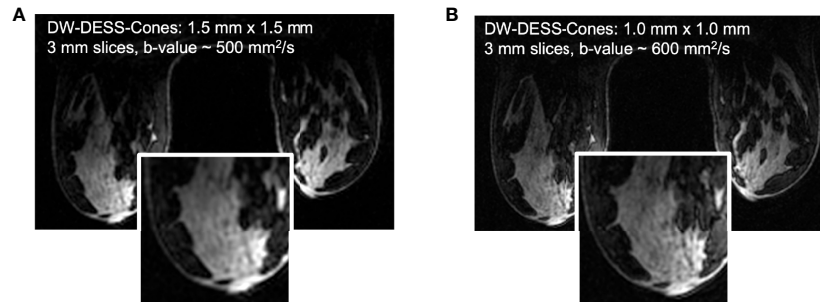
Based on the results of the initial DW-DESS-Cones investigation in the breast at 3T (A), the diffusion-weighting and resolution of the method can be further increased (B) to better match contrast and resolution expectations for breast MRI (109). (Courtesy of Catherine Moran, PhD, Department of Radiology, Stanford University, Stanford, California, USA).
